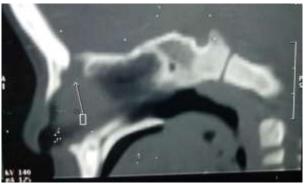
CT scan showing soft tissue lesion superior to bony septum with communicating sinus tract to nasal tip with 5.8 mm bony defect in anterior cranial fossa.
